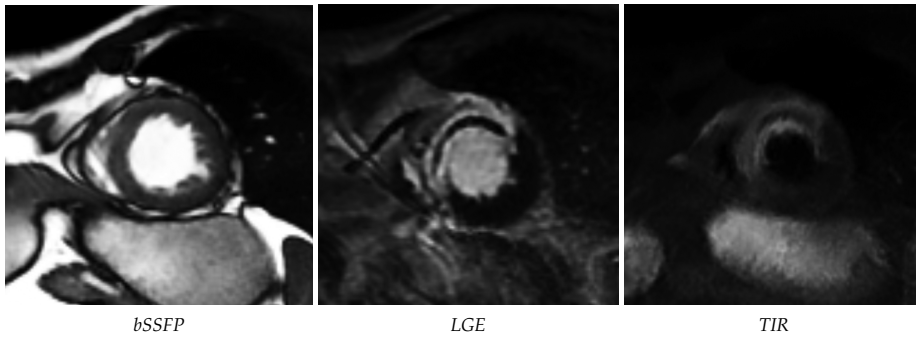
MRI images for the same patient with three different sequences: balanced Steady State Free Precession (SSFP) sequence for anatomical evaluation, late gadolinium enhancement (LGE) sequence for necrotic/fibrotic tissue evaluation and triple inversion recovery sequence (TIR) for oedema evaluation.
